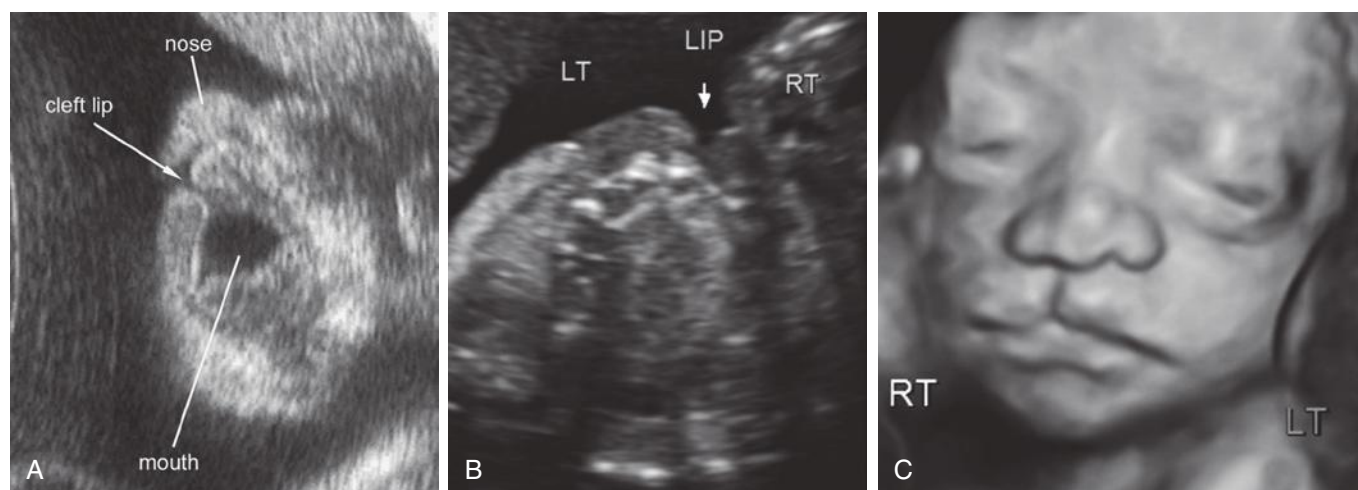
Unilateral right cleft lip in fetus at 27 weeks: A, Frontal two-dimensional ultrasound image of lip and nose showing cleft lip (arrow). B, Axial two-dimensional image of palate showing intact primary and secondary palate with unilateral right cleft lip (arrow). C, Frontal three-dimensional surface rendered image of right unilateral cleft lip.
